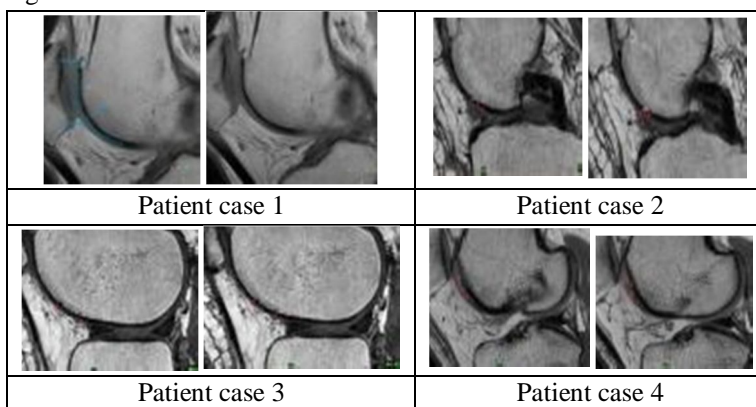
Conventional MRI showing lack of biochemical insights but showing structural changes.
